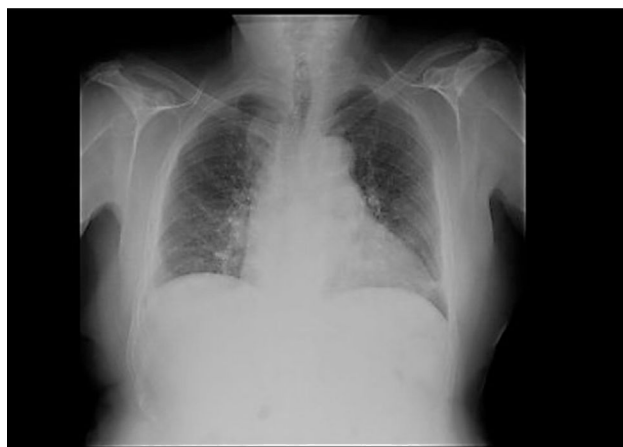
Posteroanterior chest x-ray with atelectasis in the lower left lobe of the lung.
